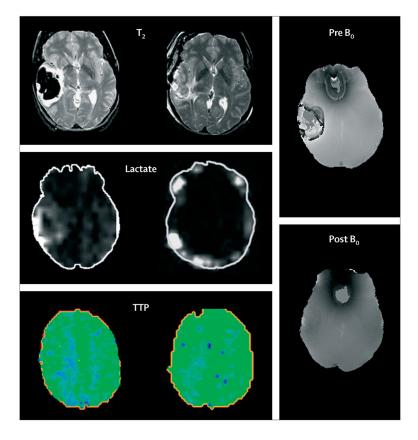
Advanced MRI of lobar intracerebral haemorrhage
